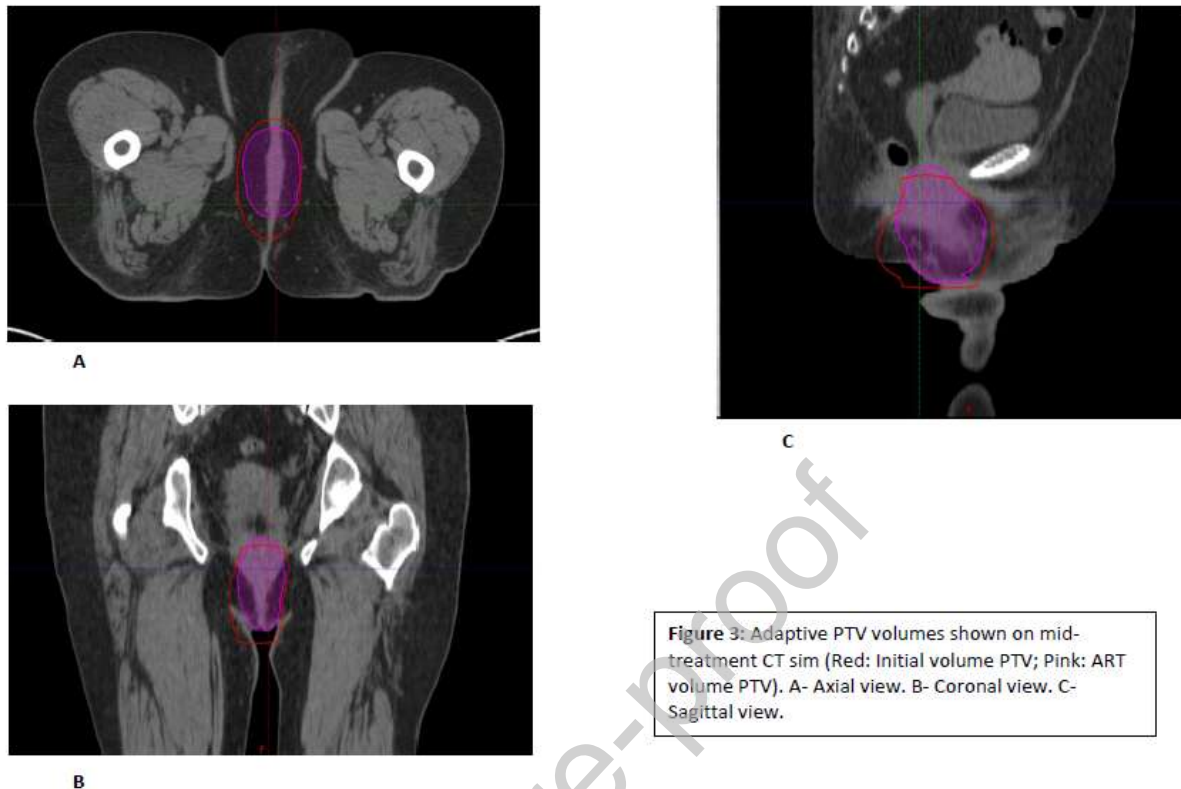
Adaptive PTV volumes shown on mid-treatment CT sim (Red: Initial volume PTV; Pink: ART volume PTV). A- Axial view. B- Coronal view. C- Sagittal view.
